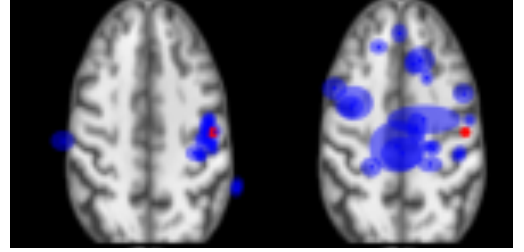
Visualization of Patch2Loc’s output (blue ellipses) for patches captured from the same location (red dot) across different subjects in the BraTS dataset, overlaid on a representative T1-weighted registered slice (without abnormalities). (Left) Predictions of normal patches. (Right) Predictions of abnormal patches. The predicted Gaussian distribution is visualized as an ellipse, where the center represents the predicted mean, and the major and minor axes correspond to two standard deviations.
